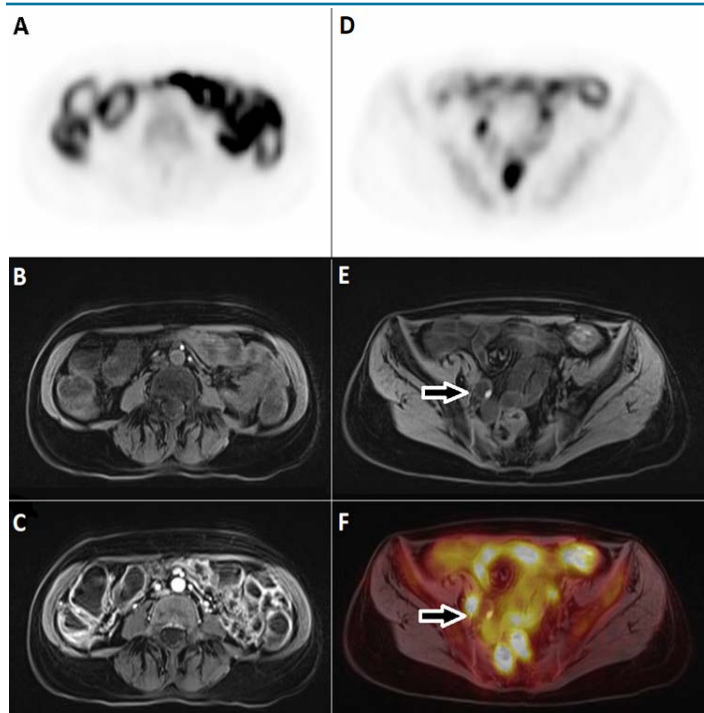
PET images at two levels in the abdomen and pelvis, along with simultaneously acquired pre- and post- TR1 MRI. A, B and C demonstrates the widespread FDG uptake on PET sequence and corresponding contrast enhancement, consistent with colitis, potentially masking serosal deposits. D and E demonstrates another level in the abdomen with persistent FDG uptake in the bowel, but a focus of high-intensity T1 signal (arrow) visible on pre-contrast MRI consistent with serosal disease. The fused image F, of the same slice shows a non FDG avid focus, compatible with treated disease.
